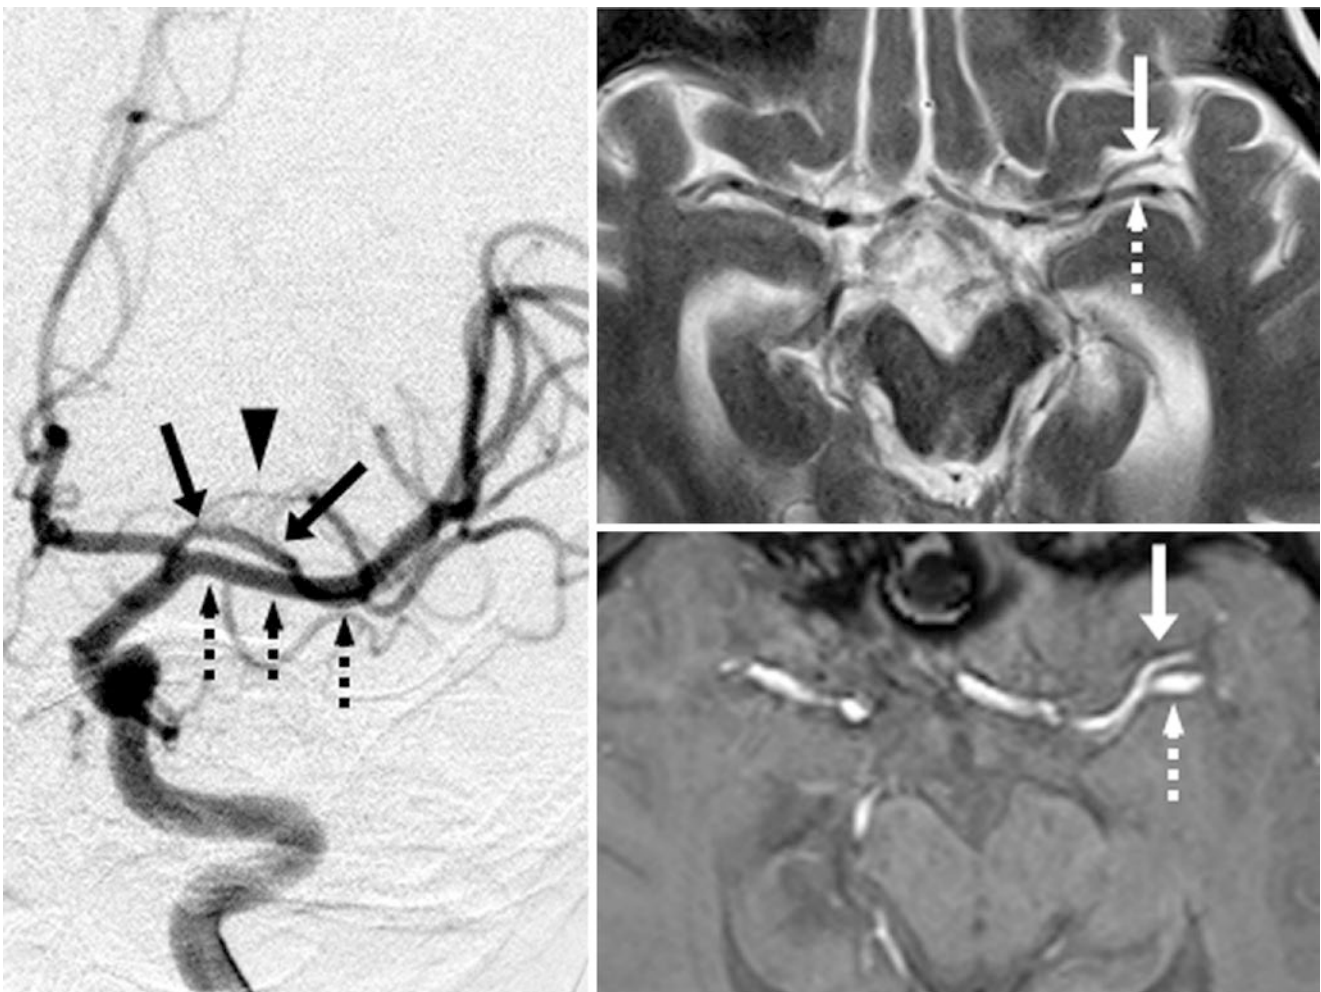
An accessory left MCA (*arrows*) is shown to arise from the left A1 segment on a catheter DSA AP view (*left*) and on 3 T MRI T2WI (*right, top*) and SWI (*right, bottom*). Note (*dotted arrows*) denote the “M1 segment” lenticulostriate arteries (*arrowhead*)
